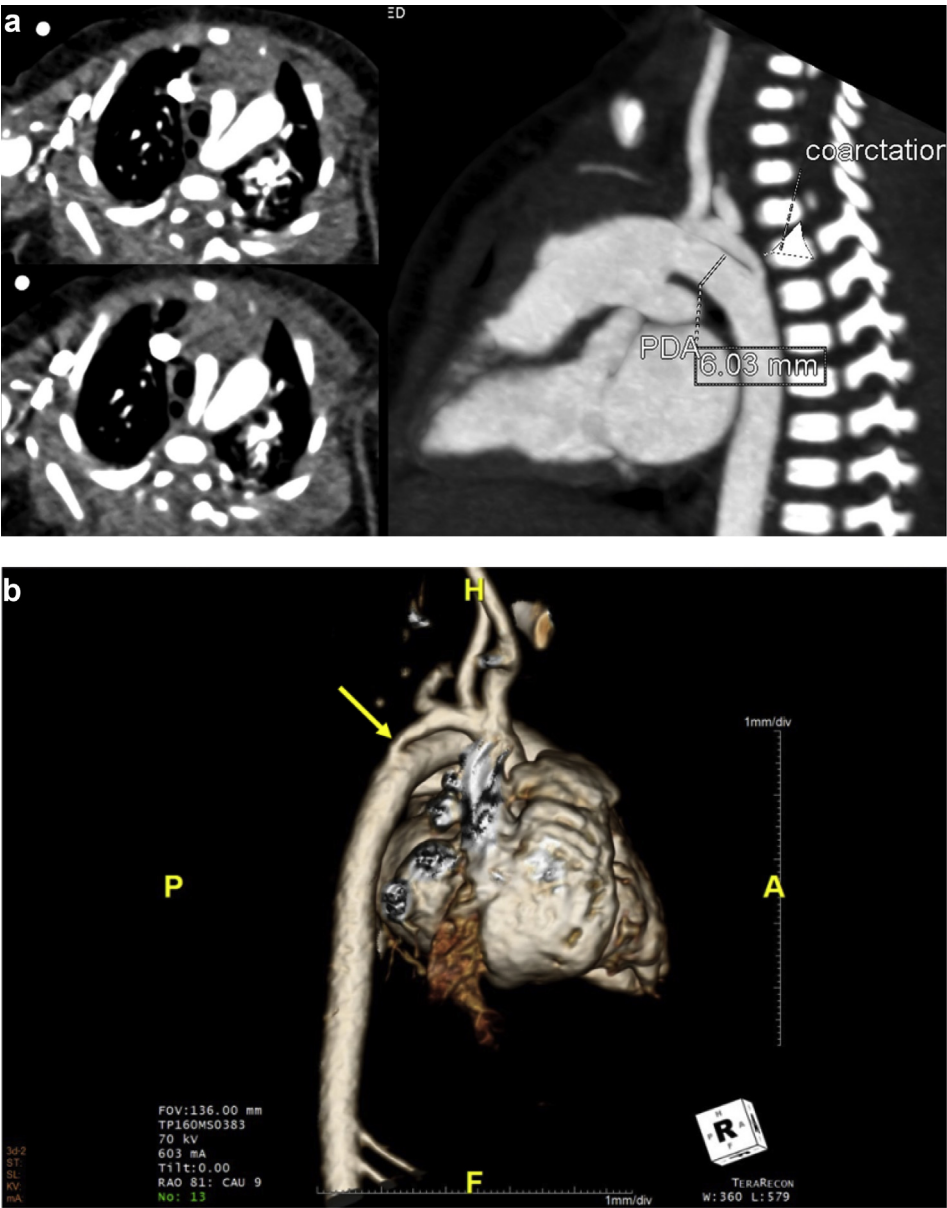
a. Cardiac CT scan. Aortic arch hypoplasia and patent ductus arteriosus 6.03 mm. b. Cardiac CT scan, 3D image. Aortic arch hypoplasia.
